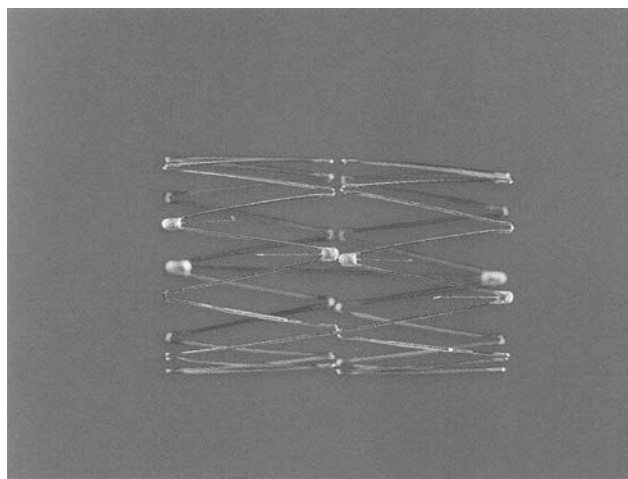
Postinterventional CT scan demonstrating proper position of the stent
